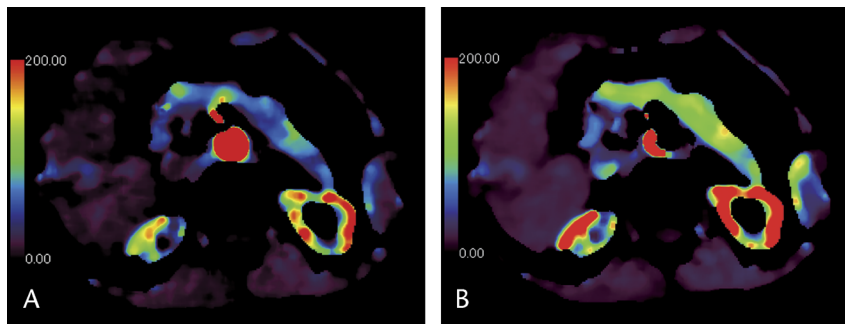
Perfusion CT of the pancreas created by the maximum-slope method (A) and compartment-model method (B). Both techniques provide similar images, but the obtained pancreatic parenchymal perfusion was slightly lower in the maximum-slope method compared with the compartment-model method.
